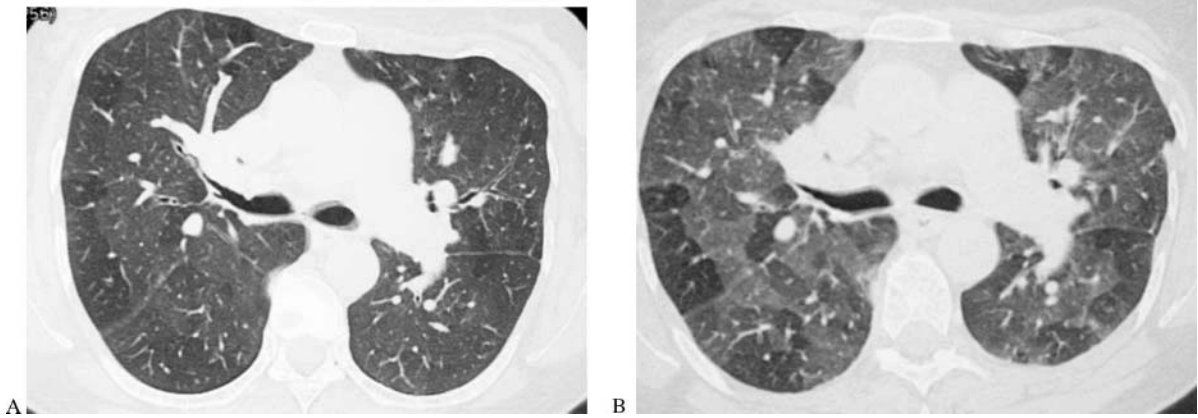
Obliterative bronchiolitis in a middle-aged woman with rheumatoid arthritis. (A) Inspiratory HRCT scan demonstrates a typical mosaic perfusion pattern. (B) High-resolution CT obtained at end-expiration shows patchy lobular areas of air trapping.
